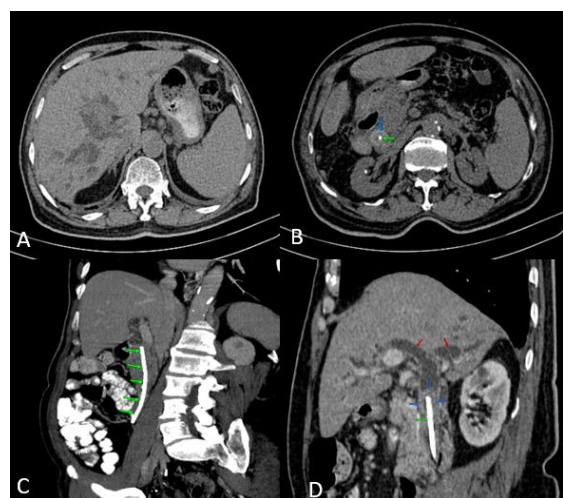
Axial non contrast image of the computed tomography of the abdomen (A, B) shows severe dilatation of the intrahepatic biliary radicles and a lamellated
